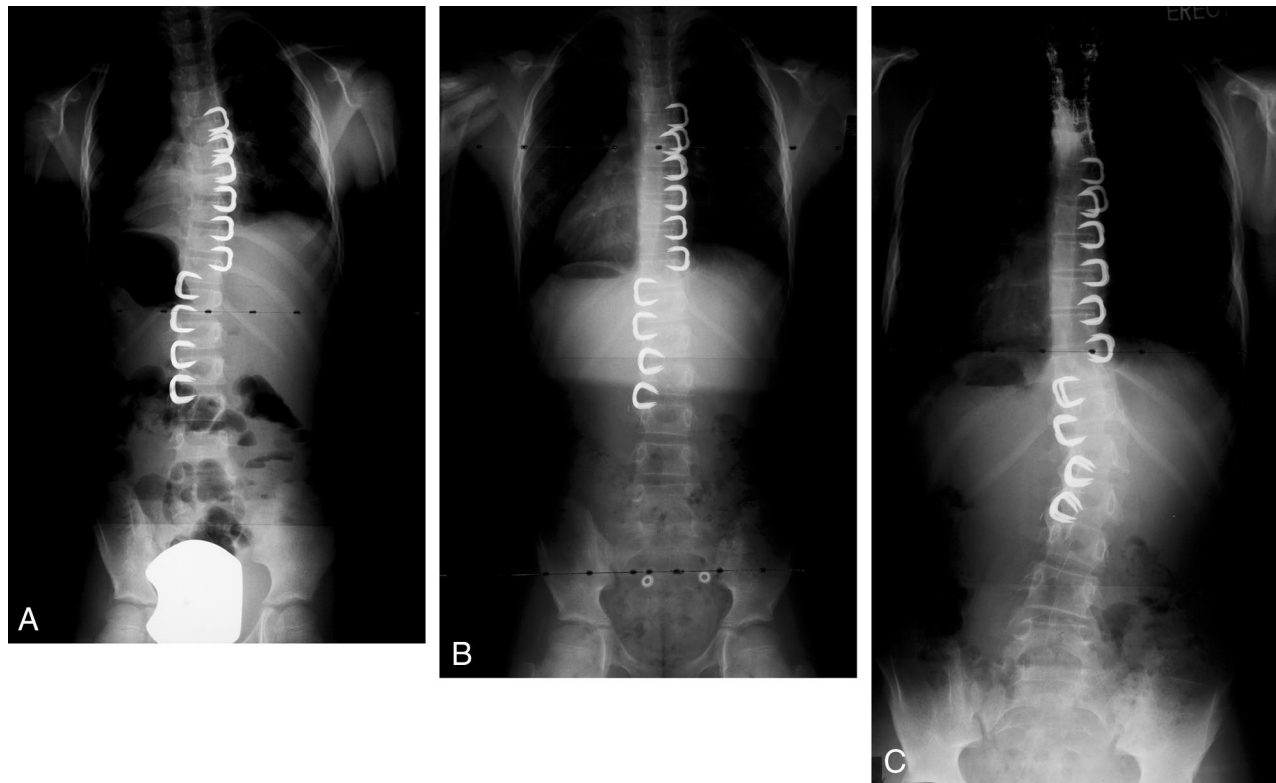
A, This is a 6-year-old female with a 21° thoracic curve and a 25° lumbar curve. She underwent thoracoscopic vertebral body stapling from T5–T11 on the right side and, on the left, had vertebral body stapling through a mini-open incision from T11 to L3. B, The PA radiograph at 2 years postop shows maintenance of the curve correction in the thoracic spine and the beginnings of overcorrection in the lumbar spine, specifically seen between the L1 and L2 vertebrae. C, PA radiographs from 4 years postsurgery show overcorrection of the lumbar spine and beginnings of overcorrection in the thoracic spine. The lumbar staples were then removed, but there turned out to be spontaneous fusion between L1 and L2 causing permanent reverse deformity of the lumbar curve.
